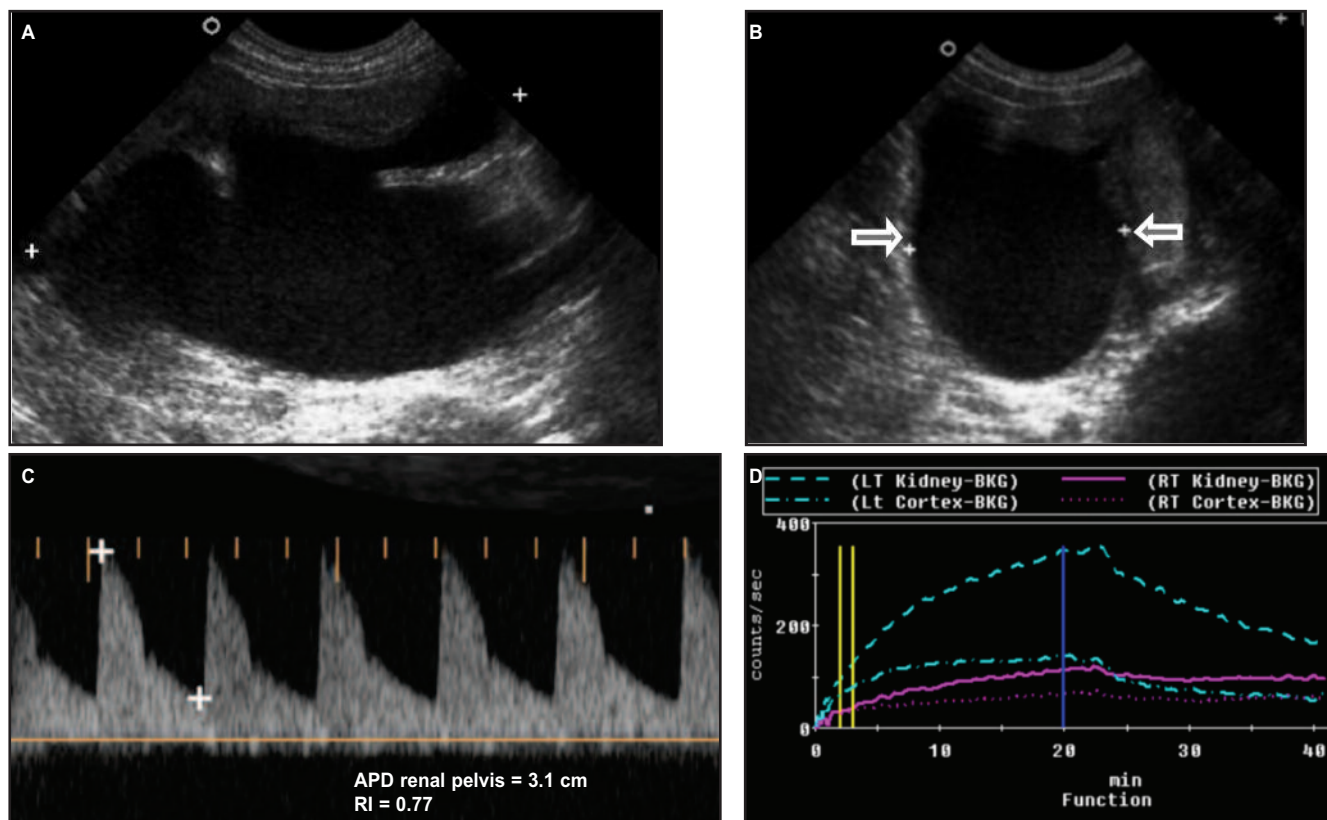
A false positive case: 11-month-old boy with bilateral Grade V vesicoureteric reflux. Ultrasound images show gross hydronephrosis of the left kidney A. in longitudinal plane B. in transverse plane, with renal pelvic APD of 3.1 cm. C. Spectral Doppler yielded resistive index of 0.77. D. Dynamic renal scintigraphy confirmed non-obstructive hydronephrosis. (APD = anteroposterior diameter).
